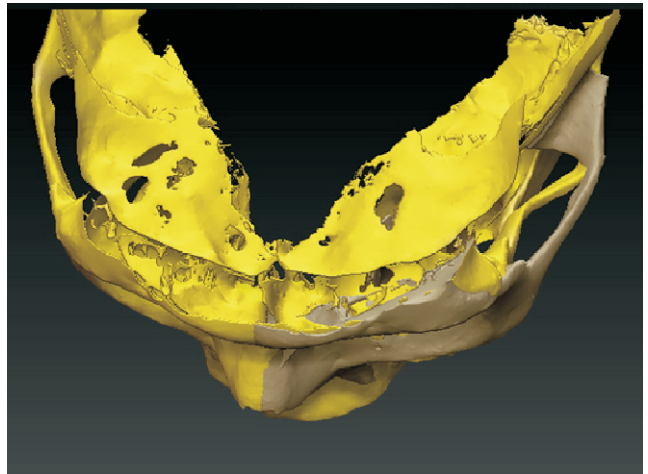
3D reconstruction of computed tomography data
